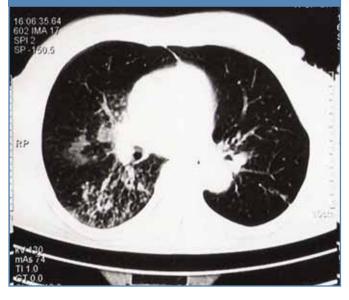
Contrast enhanced computed tomography of the thorax showing the multifocal nature of bronchial stenosis. Consolidation of the right middle lobe with air bronchograms was also seen.
